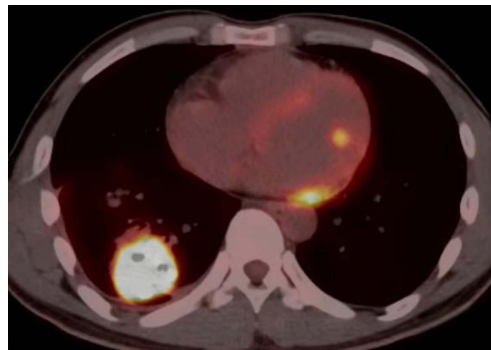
PET-CT showed right lower lung mass with abnormal FDG concentration and SUV_{max} of about 16.5.
